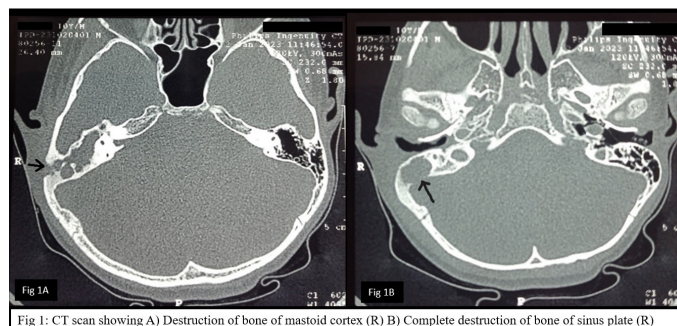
CT scan showing A) Destruction of bone of mastoid cortex (R) B) Complete destruction of bone of sinus plate (R)
